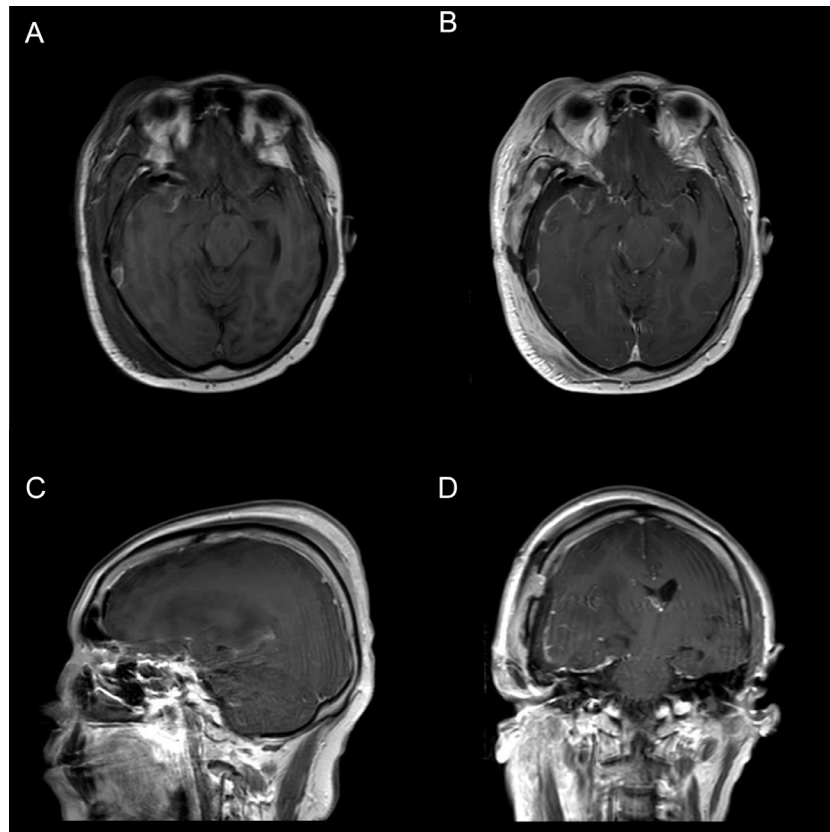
Postoperative MRI images with gadolinium. (A) MRI: Post-Operative Axial T1 SE Non-Contrasted (B) MRI: Post-Operative Axial T1 SE + Gadolinium Contrast. (C) MRI: Post-Operative Sagittal T1 SE + Gadolinium Contrast (D) MRI: Post-Operative Coronal T1 SE + Gadolinium Contrast.
